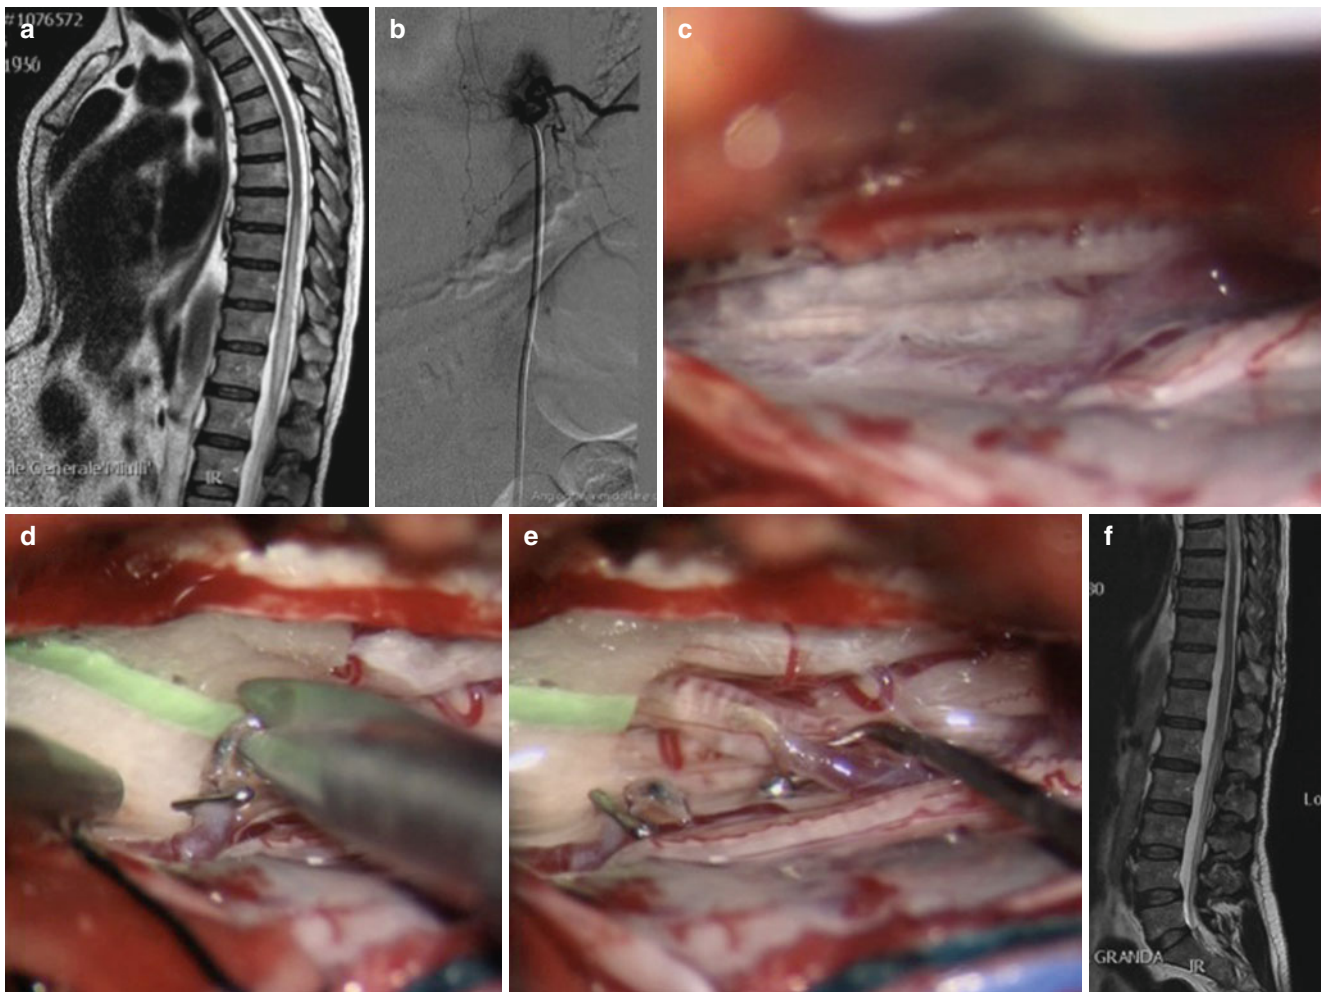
(a) A spinal MRI in a patient with progressive myelopathy showing a hypersignal in the spinal cord due to venous engorgement. Note the little flow void on the posterior aspect of the cord. (b) Spinal DSA confirms the suspicion of a type II dorsal sDAVF. (c–e)
